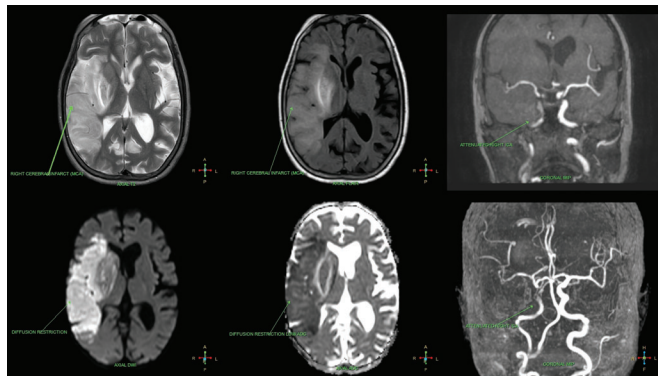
Contrast-enhanced magnetic resonance imaging and magnetic resonance angiography images suggest an acute infarct in right fronto-parieto-temporal region with mild oedema along with relative narrowing of the right internal carotid artery, A1 segment of right anterior cerebral artery and middle cerebral artery with thinning of the M3 and M4 branches of right middle cerebral artery
